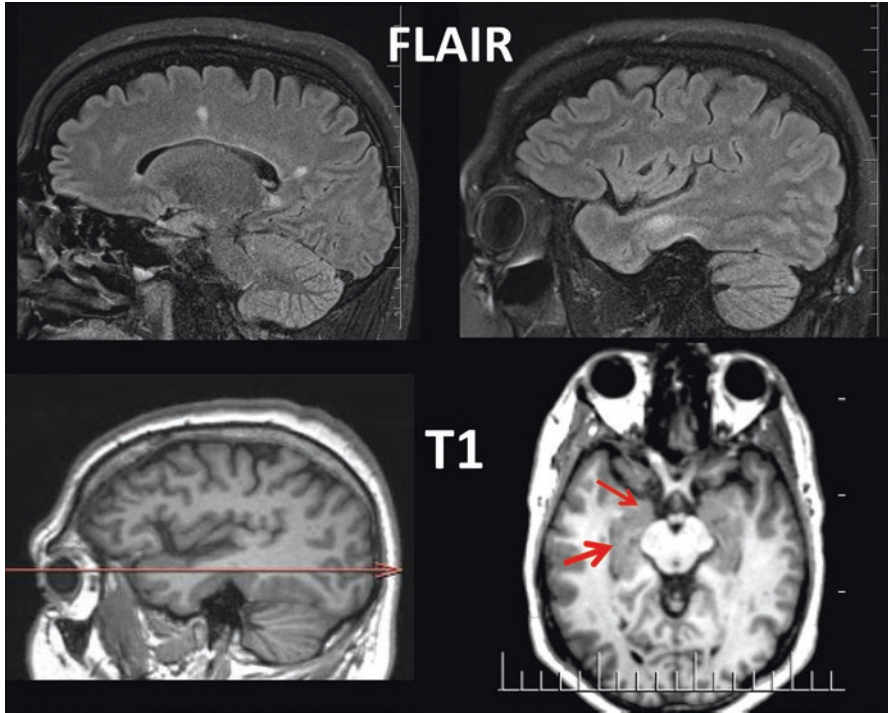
Sagittal FLAIR images at the level of the outer margins of the corpus callosum and beginning of the corona radiata (left) through the temporal stem of the temporal lobe (right). The anatomical sagittal T1 at the bottom left shows the plane for the axial cut, and the bottom right depicts the location of the hyperintense signal in the temporal lobe adjacent to the hippocampus (bottom arrow) and amygdala (top arrow)
